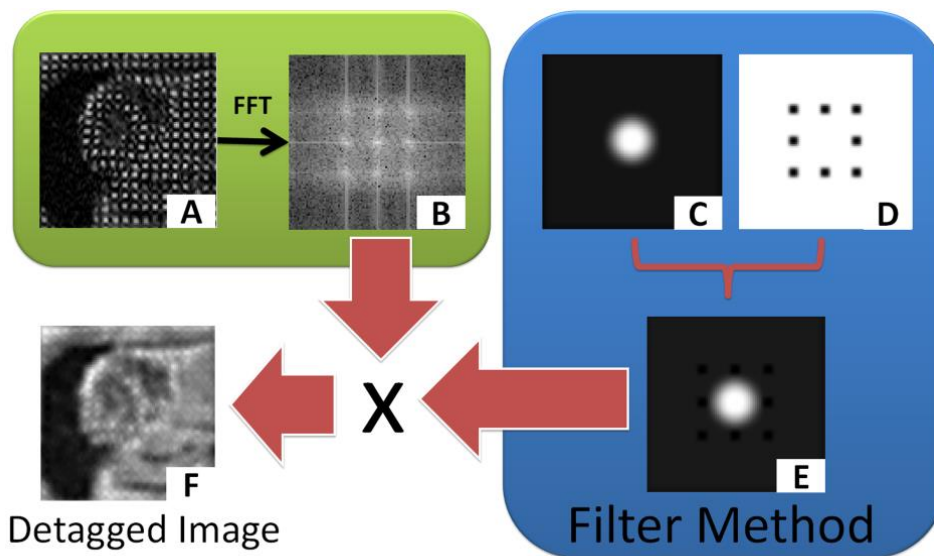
Method used to suppress the tags in the t-MRI images.
